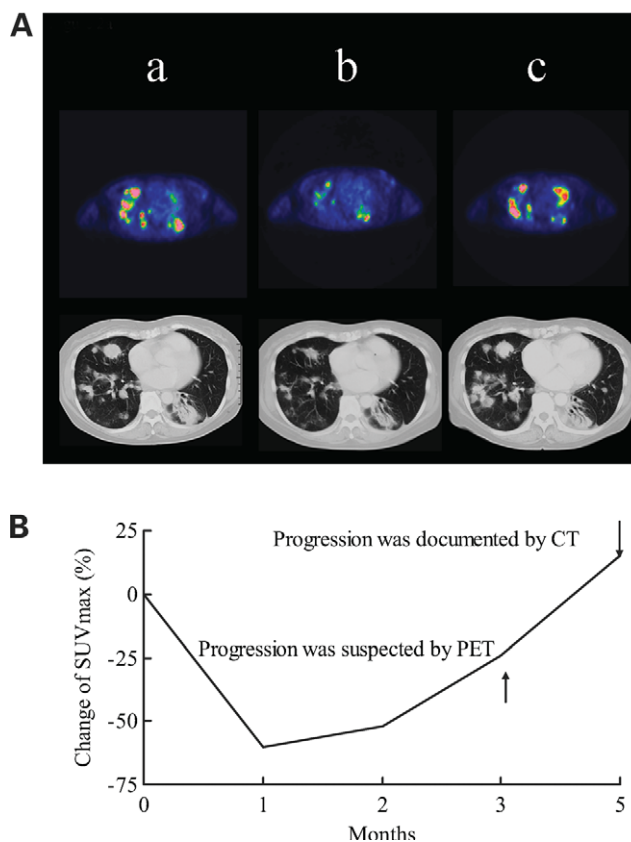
(A) Comparison of FDG-PET and CT with trastuzumab-resistant breast cancer with lung metastases. Partial response was documented by CT. a, before the treatment; b, the major reduction in FDG uptake and objective tumor response was observed after 1 month of treatment; c, disease progression was confirmed by CT after 5 months of treatment. (B) The time course of the SUVmax and tumor response in a patient with breast cancer with partial response was documented by CT. The SUVmax was decreased by 60% from baseline after 1 month of treatment. The SUVmax began to increase 2 months before progression was documented by CT.
